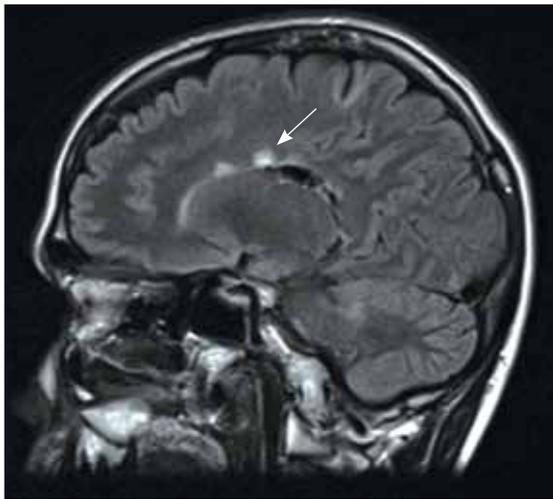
Sagittal view of the brain, showing multiple pericallosal hyperintense lesions (arrow) on fluid attenuation inversion recovery (FLAIR)
